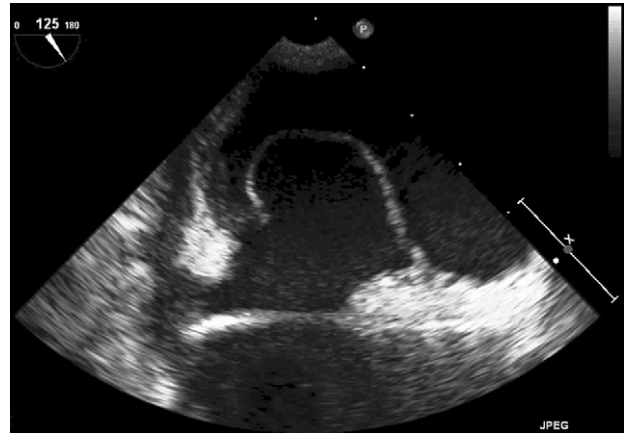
A transesophageal echocardiography image showing the large atrial septal aneurysm protruding into the left atrium.
